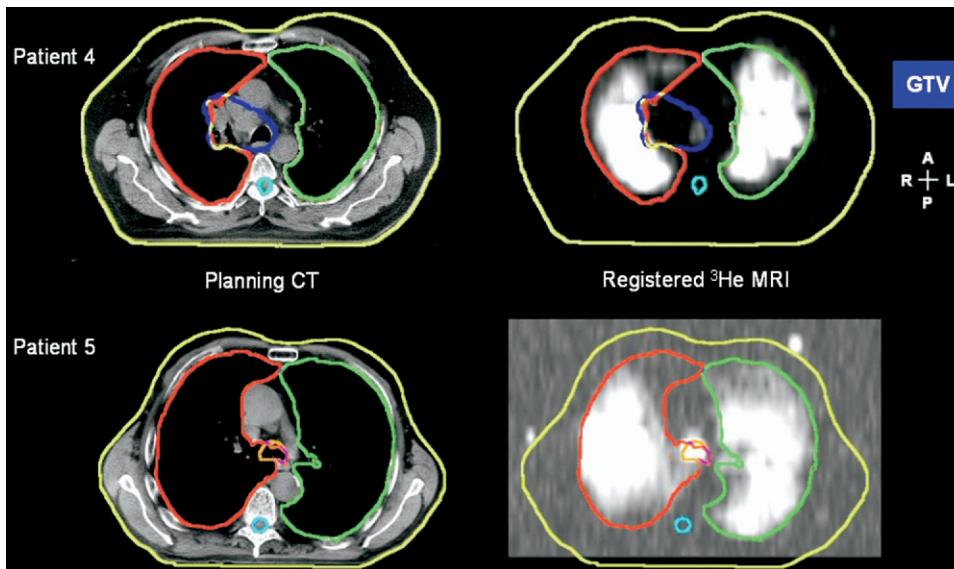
Sample registered hyperpolarized  $^3\text{He}$  magnetic resonance image (right) displayed with the external contour, left and right lung and, for Patient 4, the gross tumor volume (GTV) from the transaxial radiotherapy treatment-planning computed tomography (CT) (left).
